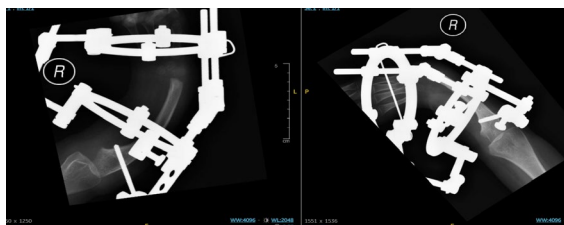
Plain radiograph during distraction
